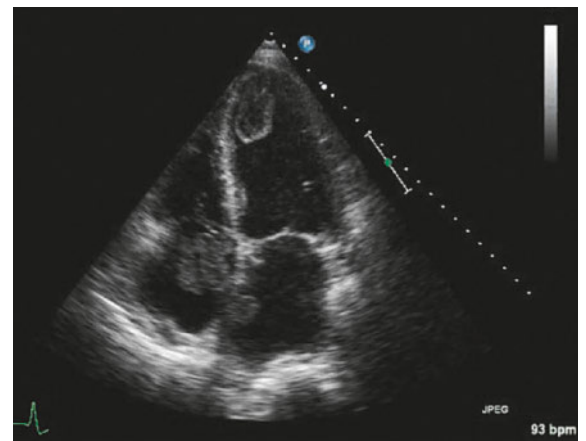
Acute myocardial infarction with severe acute heart failure. Apical four-chamber view shows a thrombus in each of the left ventricle, the left atrium and the right atrium. Thrombus in the three cardiac cavities was confirmed by autopsy.
